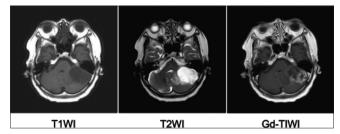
Preoperative magnetic resonance imaging showing a 35-mm sized mass in the left cerebellum that showed low intensity on T1-weighted image (left), high intensity with perifocal oedema on T2-weighted image (middle), and heterogeneous enhancement on T1-weighted image with gadolinium administration (right).
